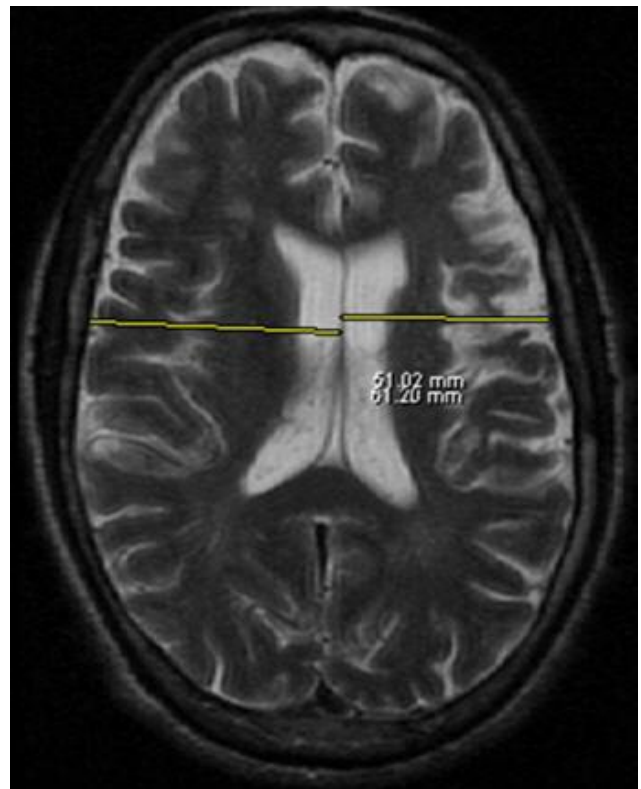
Brain MRI without contrast (axial T2 weighted sequence): Edematous changes in right parietal lobe with 5 mm right to left shift (marked by measurement lines). Mild generalized atrophy.
